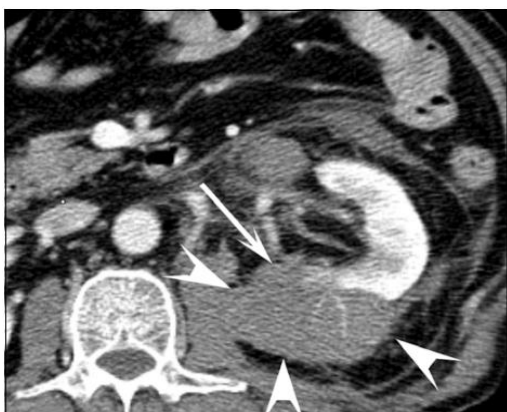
CT Grade II renal injury. Contrast enhanced CT study at corticomedullary phase showing cortical laceration (arrow) along with perinephric hematoma (arrowhead) (Quoted from Park et al.)⁽¹¹⁾
